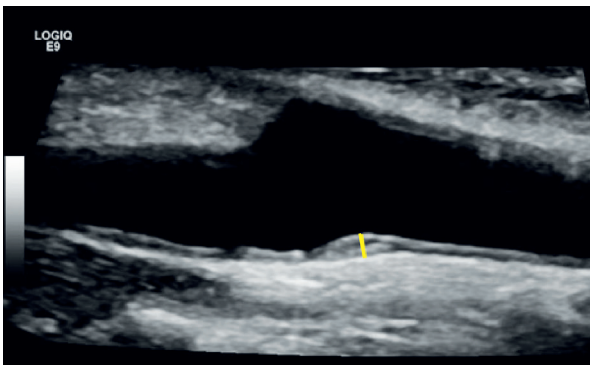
The presence of atherosclerosis promotes several changes in the arterial structure, including increased intima-media thickness (IMT), that can be assessed by vascular ultrasonography. In this example, the yellow line shows the measurement of a patient with increased IMT equivalent to 1.4 mm (VN < 1.0 mm).
